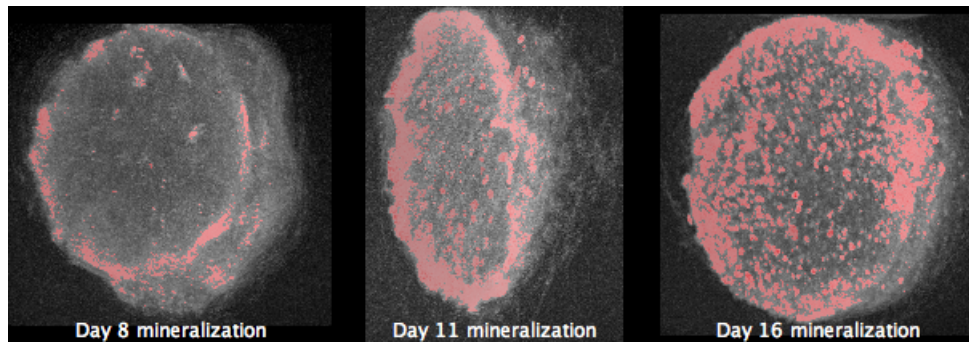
Summary of mineralized tissue (hard ECM) deposited in cultured constructs reconstructed following  $\mu$ CT of Days 8, 11, and 16, respectively. Calcium is indicated in red.
